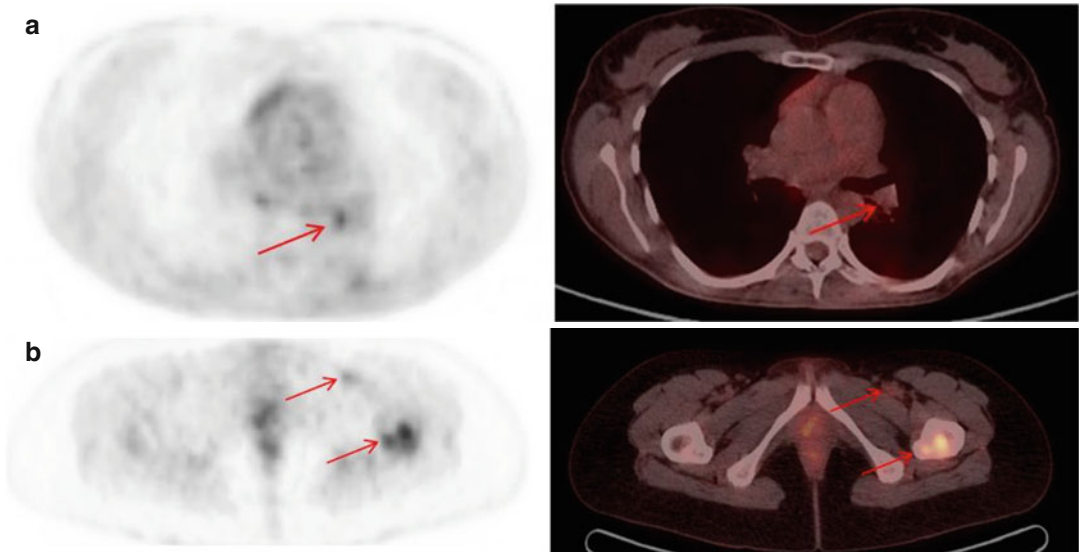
(a, b) PET/CT restaging. Mild hypermetabolism at a left hilar lymph node (a), at a deep left inguinal node, and at the left femur (b)
